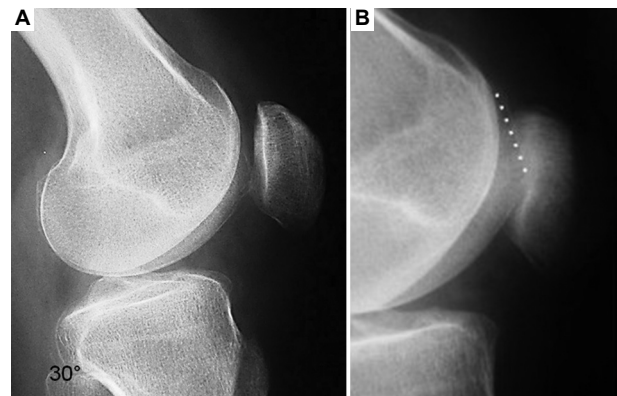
Sagittal radiographs show (A) normal trochlea and patellar height at 30° and (B) lateral patellar dislocation at 60°. The dotted line refers to the flattened mid-femoral lateral condyle. Source of image by the author.
